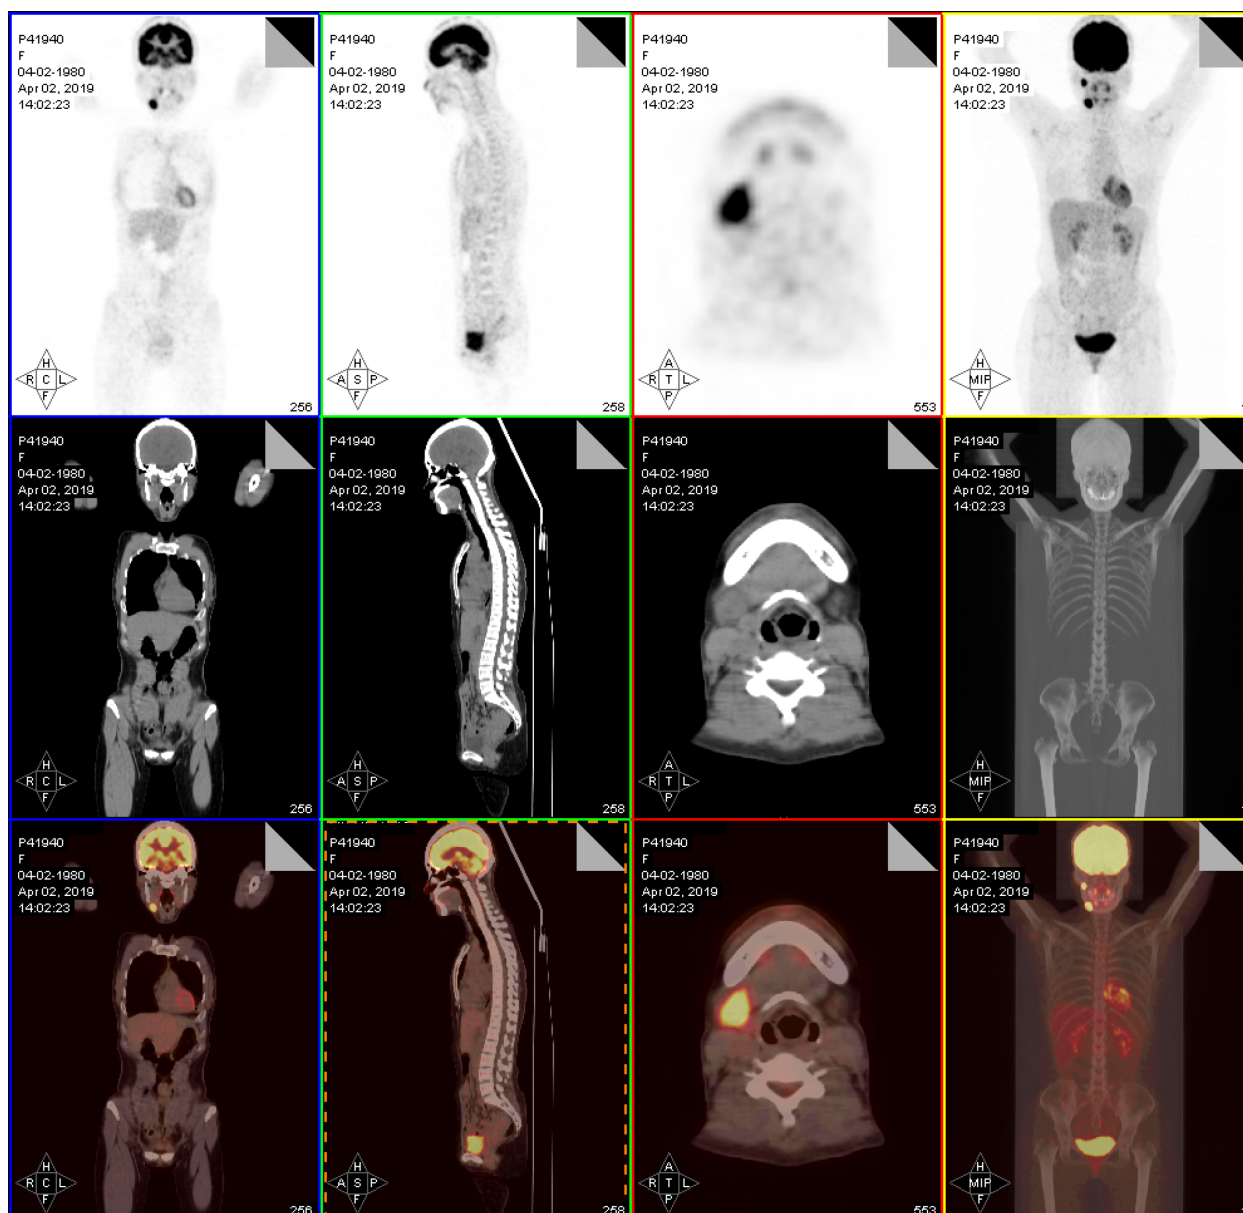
Representative fusion positron emission tomography/computed tomography images demonstrate intense uptake in the right infratemporal fossa and the lymph node of right II.
